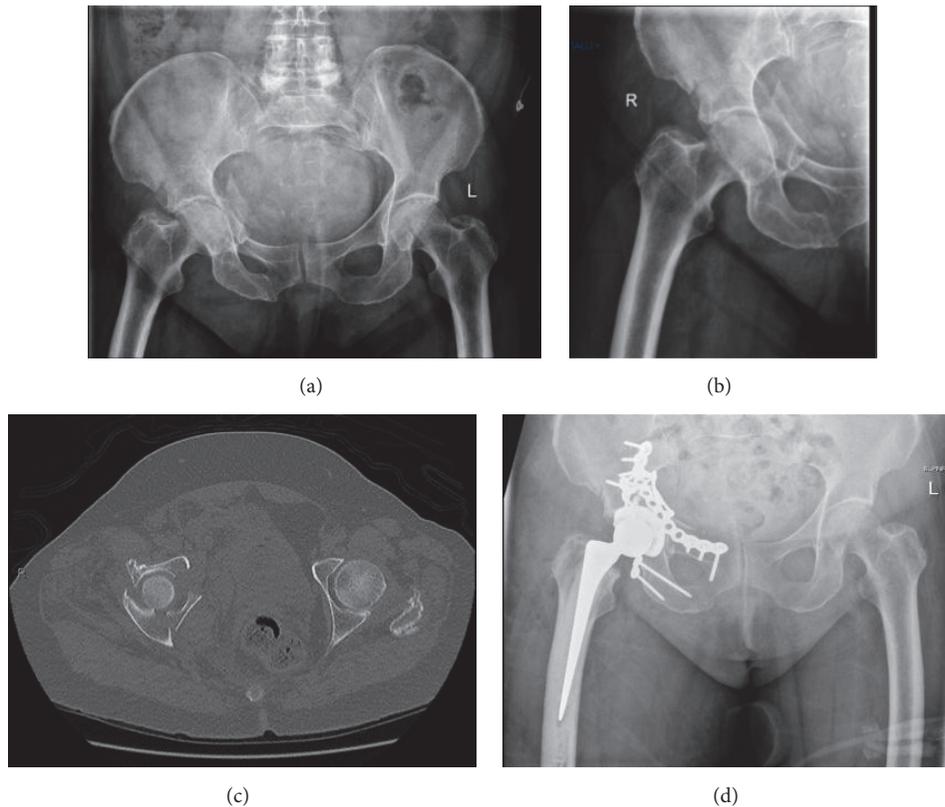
Pre- and post-op images of a typical case involving fractures of both columns. (a, b) Initial AP pelvis and film of right hip. (c) Axial CT scan of the fracture showing displacement of both columns. (d) Postoperative X-ray. Both columns have been reduced and plated, and a hip replacement was performed.
